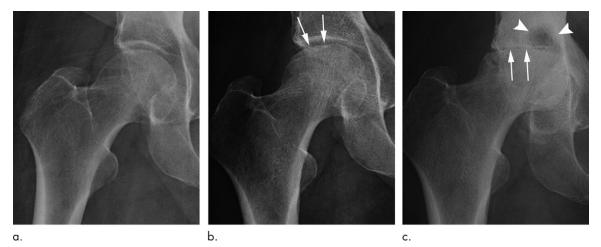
Rapid progressive osteoarthritis (RPOA) type 2 in an 81-year-old woman with right hip pain who was referred for right hip intra-articular corticosteroid injection. (a) Anteroposterior right hip radiograph shows no definite osteoarthritis. (b) Within 3 months after receiving the injection, this patient presented with worsening right hip pain. Repeat anteroposterior right hip radiograph shows subchondral insufficiency fracture, with collapse of the superior femoral head articular surface (arrows). (c) Pain increased markedly over the following month, and this repeat anteroposterior right hip radiograph shows bone loss and destruction of the femoral head with severe joint space loss, consistent with RPOA type 2 (arrows). In addition, there are extensive cystic changes at the acetabulum (arrowheads).
